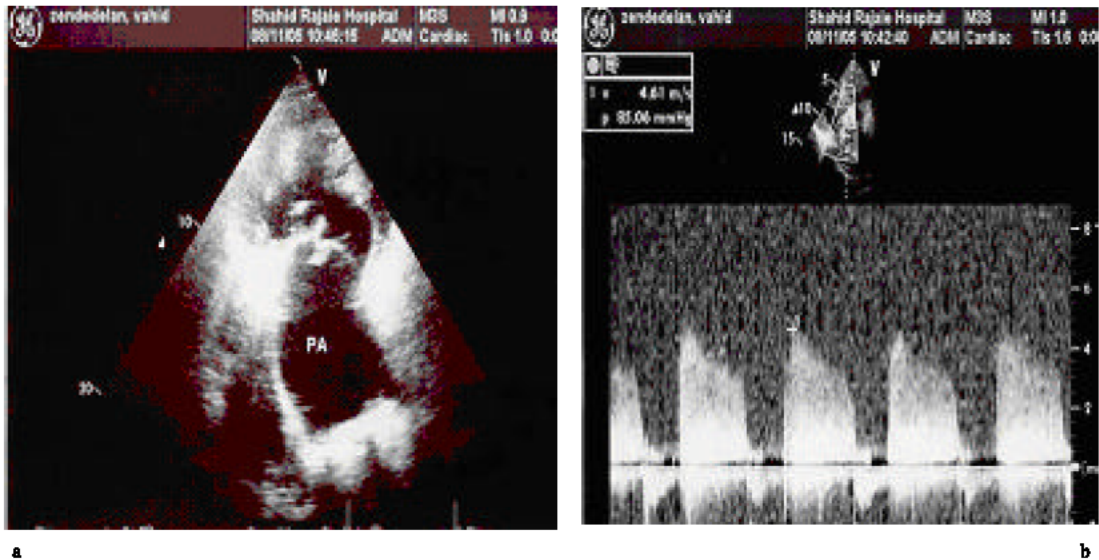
2D echocardiography revealed aneurysmal dilation of centrally located pulmonary artery (a). CW doppler showed significant pulmonary hypertension (b)
